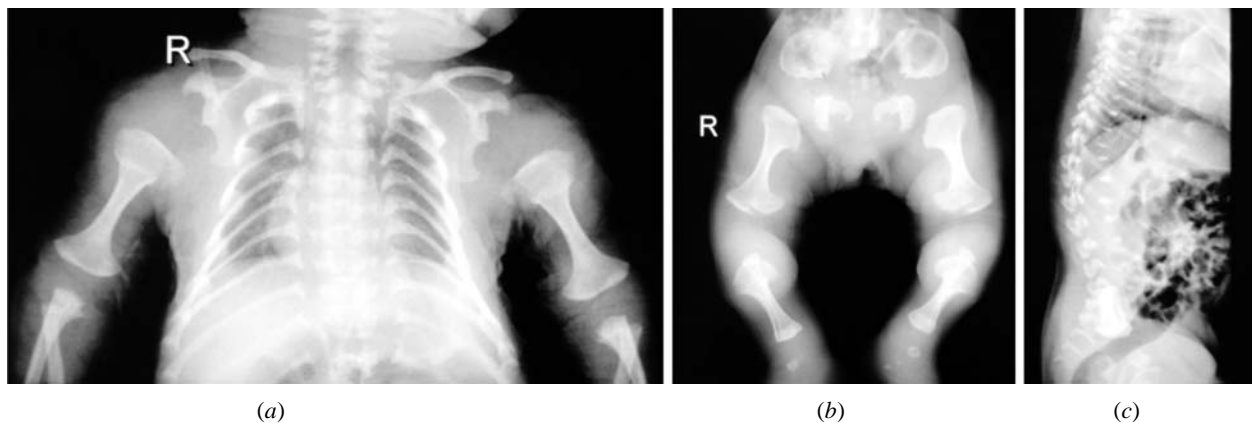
X-rays of child showing dumb bell shaped long bones (a,b), narrow thorax and short ribs with cup shaped ends (a), Halberd shaped pelvis (b), platyspondyly and wafer thin vertebral bodies (c).
